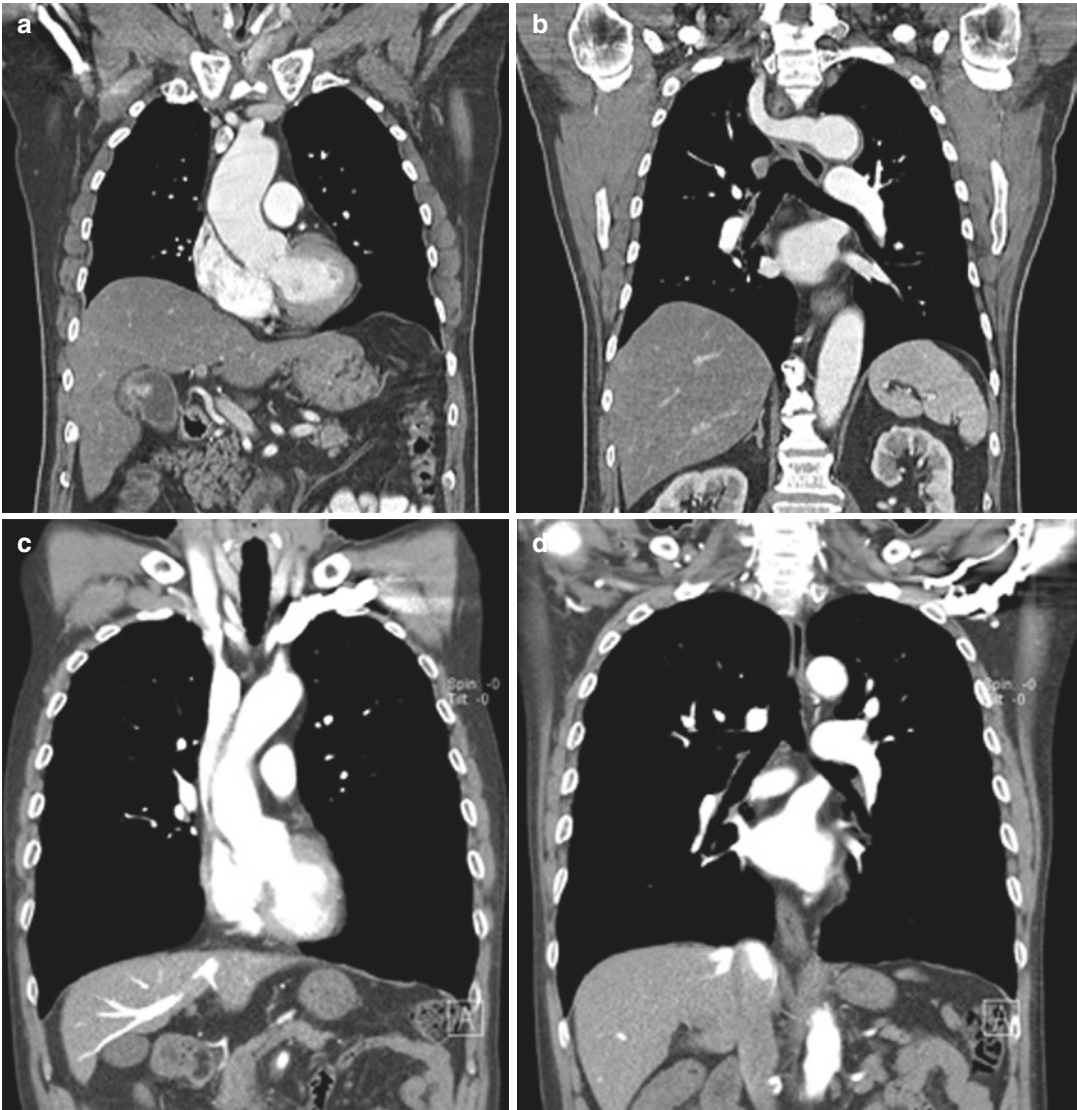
Morphologic change of the diaphragm in COPD patients. Compared with CT images in a normal individual (a, b), coronal CT images (c, d) in a 74-year-old male
